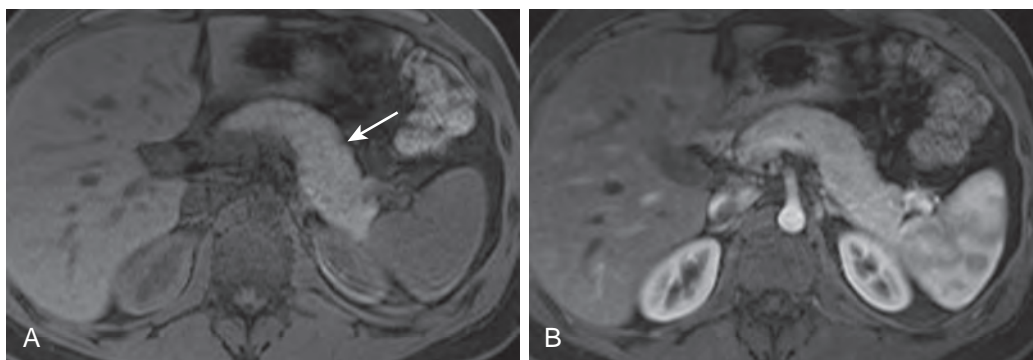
Normal MR images of the pancreas before and after gadolinium administration. A. T1-weighted fat-saturated breath-hold spoiled gradient-echo image (3.99/1.93/10) before the administration of contrast material demonstrates the normal high signal of the pancreas relative to the rest of the parenchymal organs (arrow) due to proteinaceous material within the glandular elements of the pancreas. This sequence is often the single best noncontrast sequence with which to evaluate the pancreas. B. T1-weighted postcontrast imaging with the same parameters shows an early phase of enhancement of the pancreas. Postcontrast images are routinely obtained at 60, 90, and 120 seconds after the administration of gadolinium.
